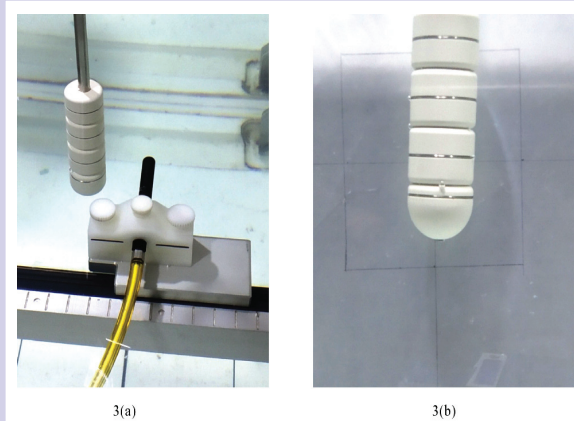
Central vaginal applicator, doses are measured with 0.125 cc ion chamber 3(a) and EDR2 radiographic film 3(b).
